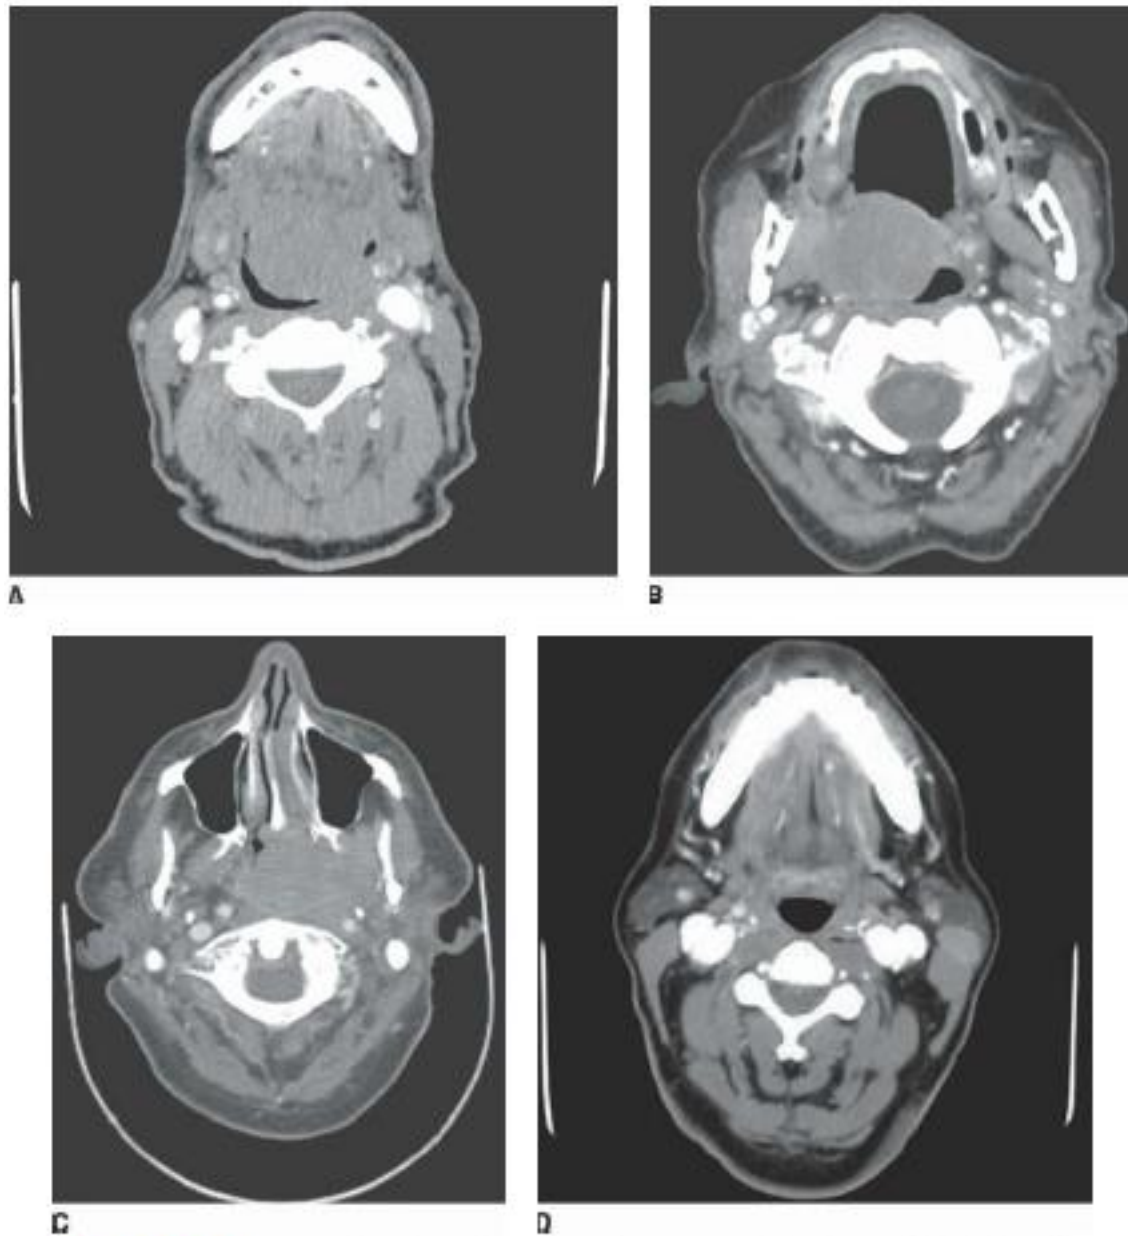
Contrast-enhanced axial CT images from patients with lymphoma of the (A) base of tongue, (B) left tonsil, (C) nasopharynx, (D) the left parotid gland.
